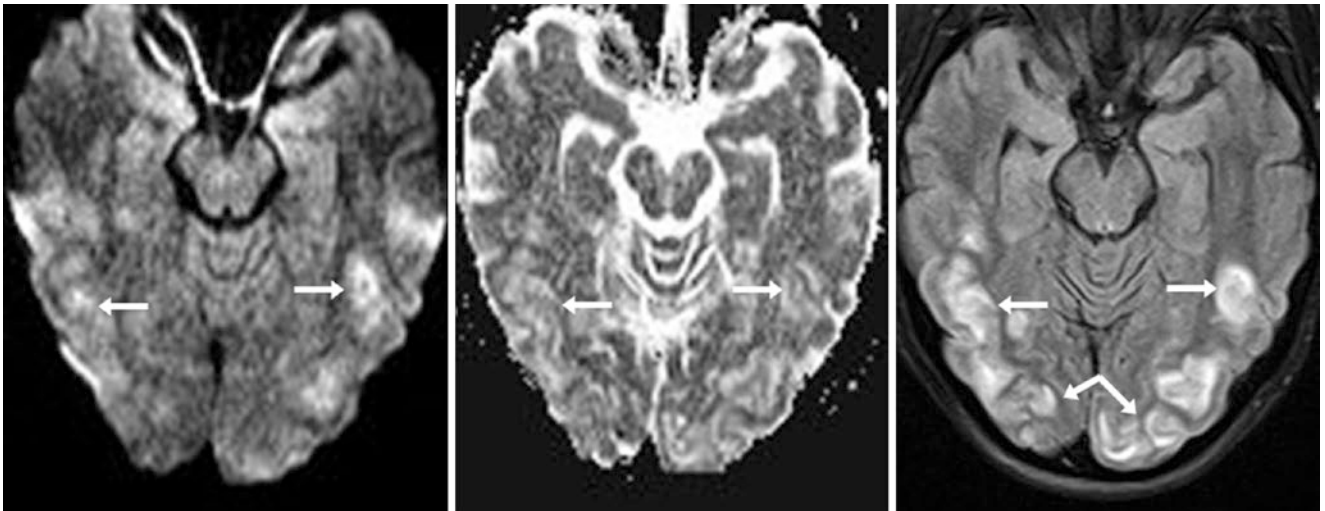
A 21-year-old with systemic lupus had a 1.5 T MRI that shows T2 shine-through bright signal (*arrows*) from PRES-related vasogenic edema within the temporo-occipital regions on DWI (*left*).
